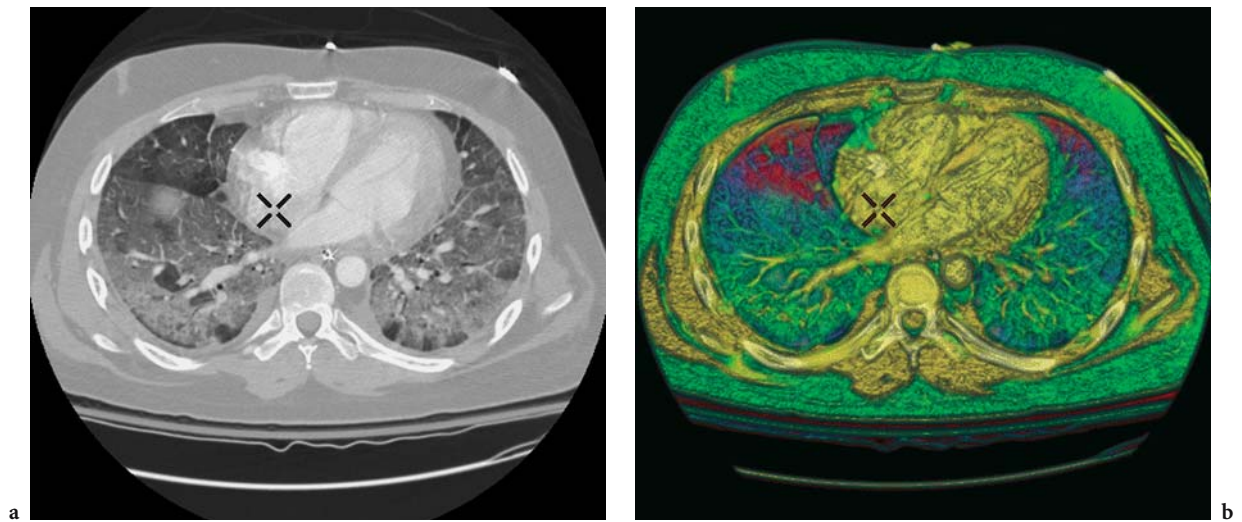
ARDS density gradient. a Scan through the lung base shows progressive increased density from ventral to dorsal. b Color coded CT shows normally aerated lung in red, ground glass areas in blue, and gravity dependent atelectasis in green
